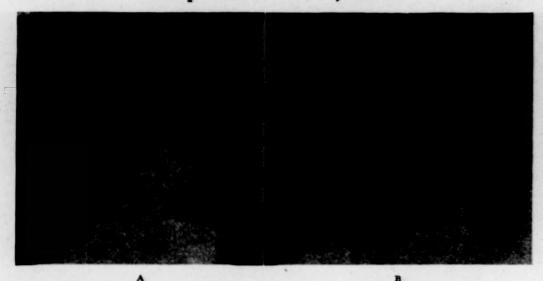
X-ray of lungs. A, April, 1943, slight increase of density at right base; B, four weeks later, generalized increase in lung markings. Diagnosis: x-ray, low grade inflammatory infection, possibly blastomycosis.
